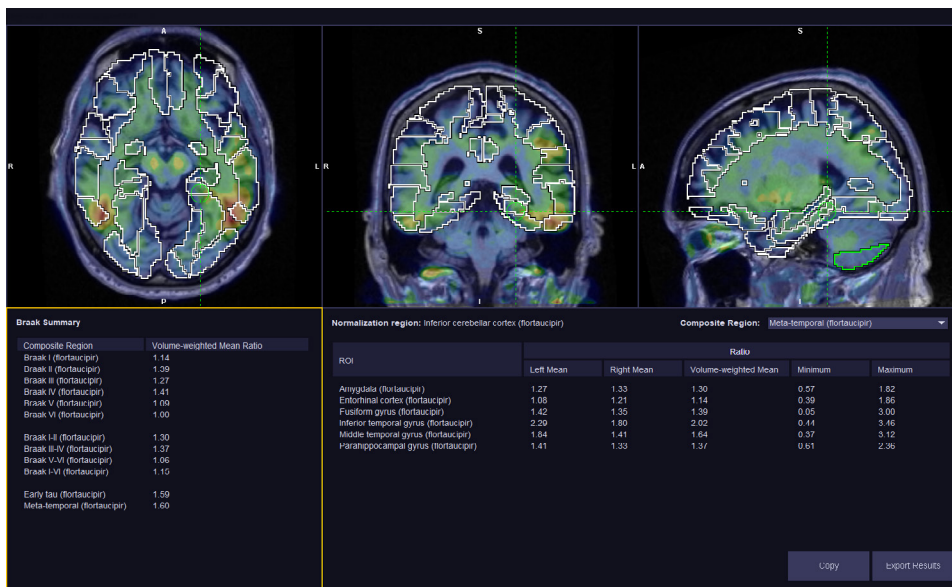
A 74-year-old A+/T+ (per visual reads) male with MCI. Abnormal and asymmetric ¹⁸F-floritaucipir uptake in the inferior temporal gyrus, the temporal pole, inferior parietal, and lateral occipital, with SUVR values for Braak I-II, Braak III-IV and Braak V-VI equal to 1.30, 1.37, and 1.06, respectively. Data from the A05 trial.
